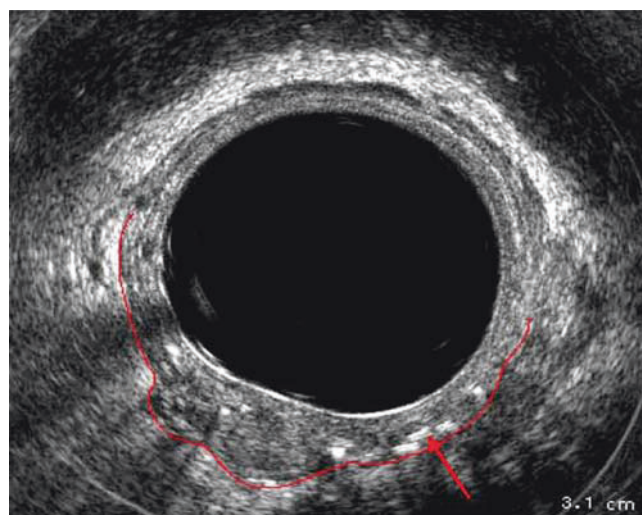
Endorectal ultrasound (ERUS) image showing recurrent rectal cancer (line) at the anastomosis. Arrow, staple line; line, delineation of locally recurrent tumor.
